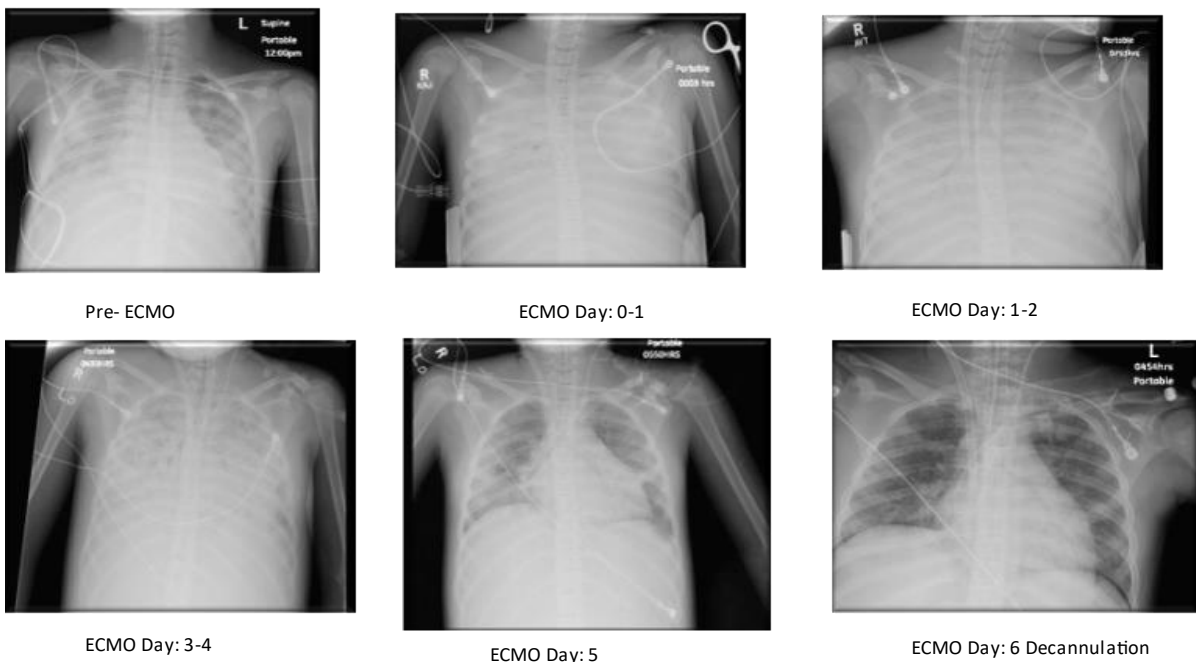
Radiographic progression of ECMO SIRS to decannulation
